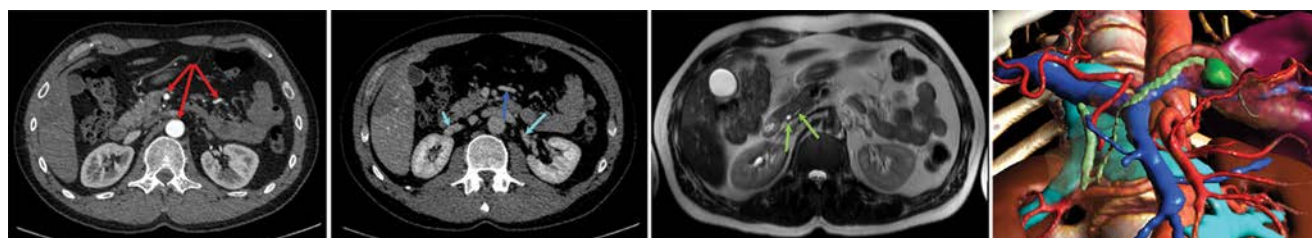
VR-Med software allowing simultaneous display and merging of different imaging modalities. CT-MRI image fusion of arteries (red arrows) segmented from the CT arterial phase; veins (blue arrows) from the CT venous phase; Wirsung and common bile duct (green arrows) from the cholangio-MRI in a single 3D virtual patient modeling.
